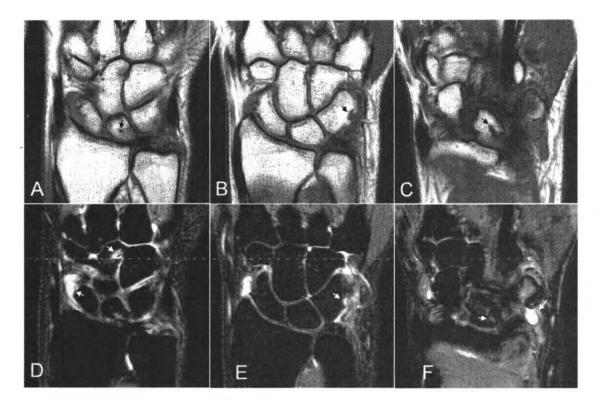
Case 2 left wrist MR images.
